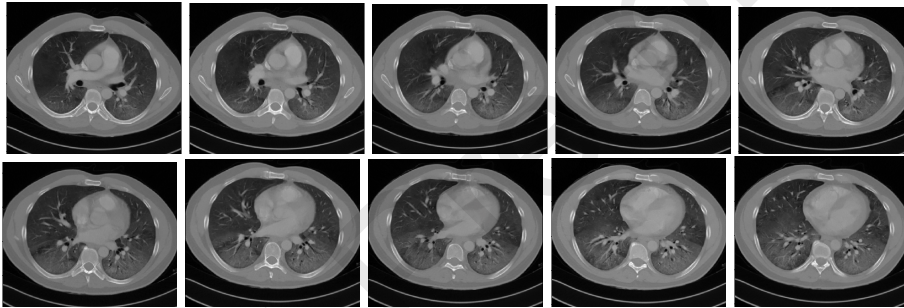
Slices from cluster center 0 of COVID-19 category in COV19-CT-DB. Bilateral ground glass regions are seen especially in lower lung lobes.
